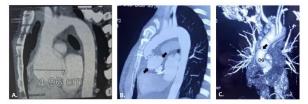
Comparison between preoperative (A) and postsurgical Computed Tomography Angiography scans (B and C). The black arrows indicate the sites of coronary buttons anastomoses in B, and the distal Dacron graft anastomosis in C. (AA: aortic aneurysm; AO: aortic orifice; LC: left coronary; RC: right coronary; DG: Dacron graft).
